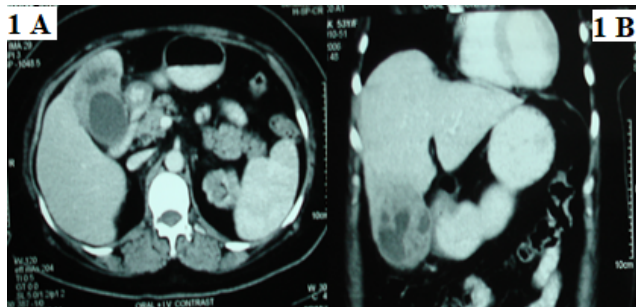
Computed Tomography (A: Axial, B: Coronal) images showing thick walled GB with band, intraluminal mass effect and infiltration of pericholecystic tissue and liver.
